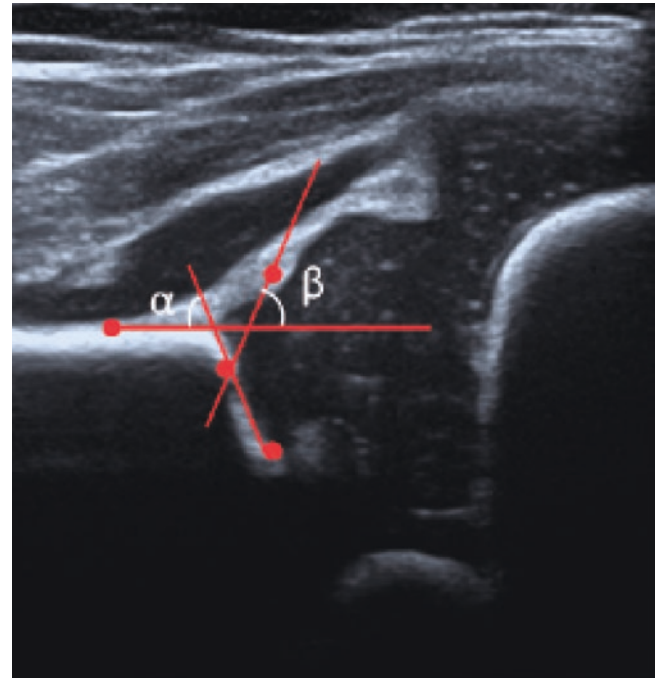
Hip ultrasound measurement
